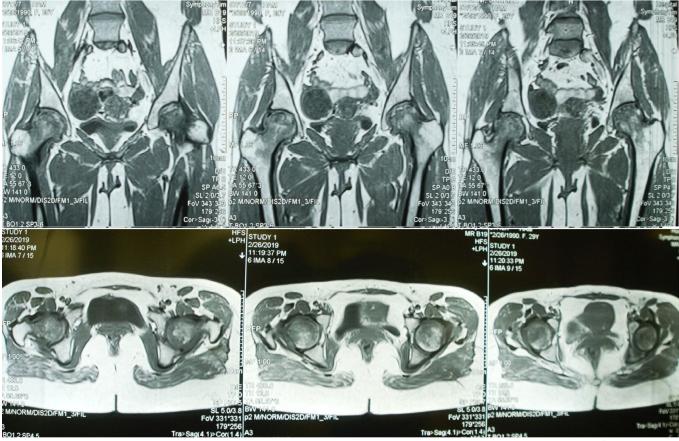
MRI of a patient who had avascular necrosis of femoral neck caused by weight gain capsule under the brand name "Fereshteh".
